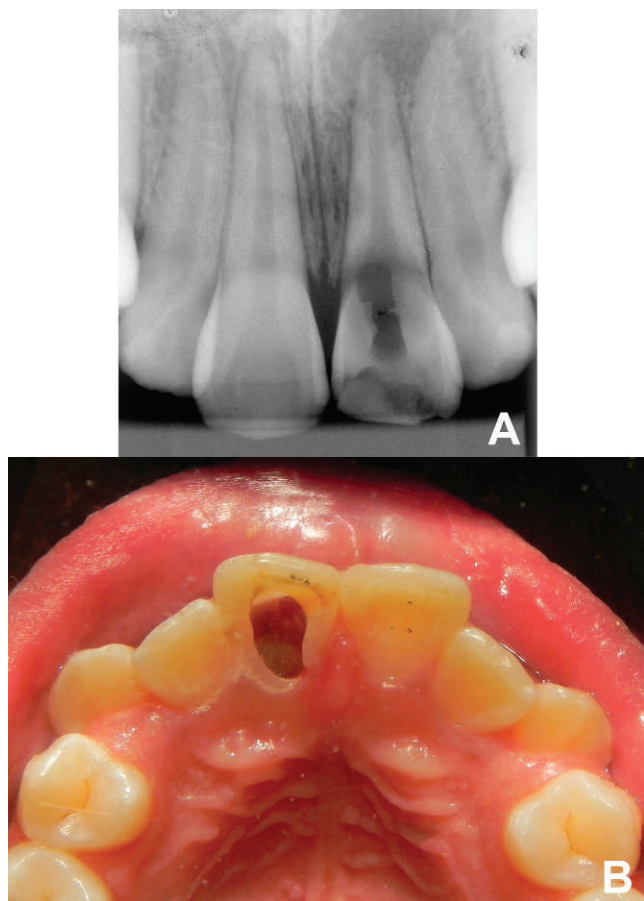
(A): Initial radiograph. (B): Occlusal view after removal of decayed tissue.
